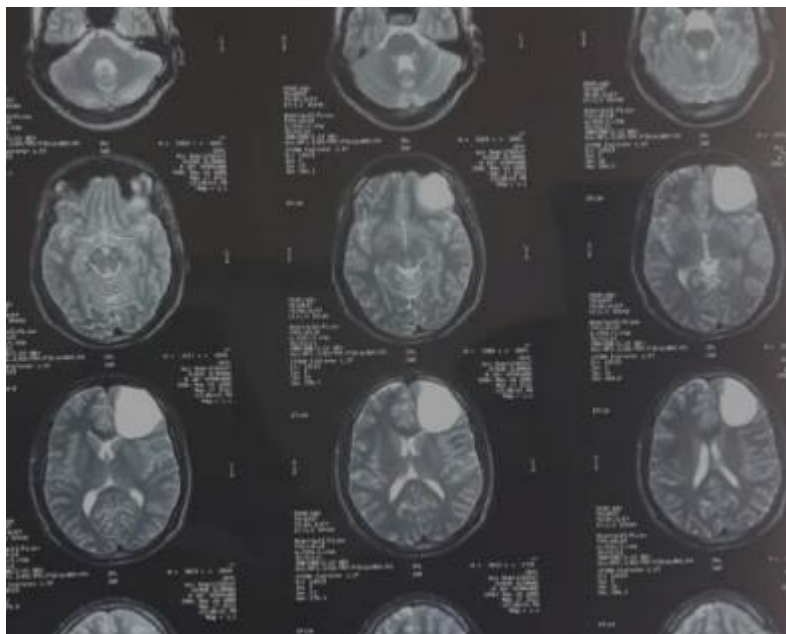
T1- weighted MRI image A large arachnoid cyst deforms the right frontal lobe; outer membrane cysts are faintly visible with overlying bony remodeling. 2b . MRI image T2 The cavity of cysts is the same signal as CSF
